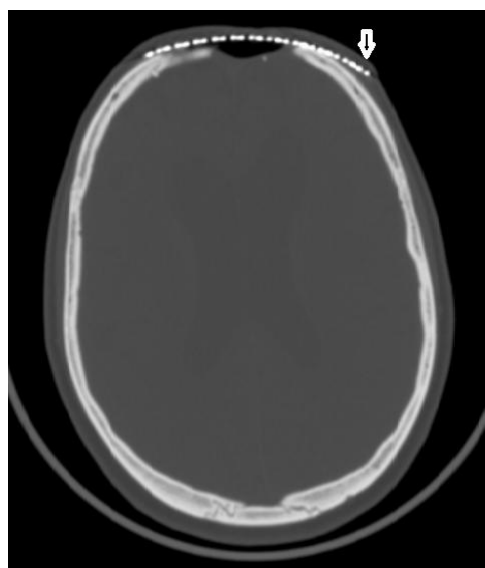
An axial CT image. The arrow points to the edge of the plate that deforms the cranial contour. The image shows the difference in geometry between the cranial vault and the implant
